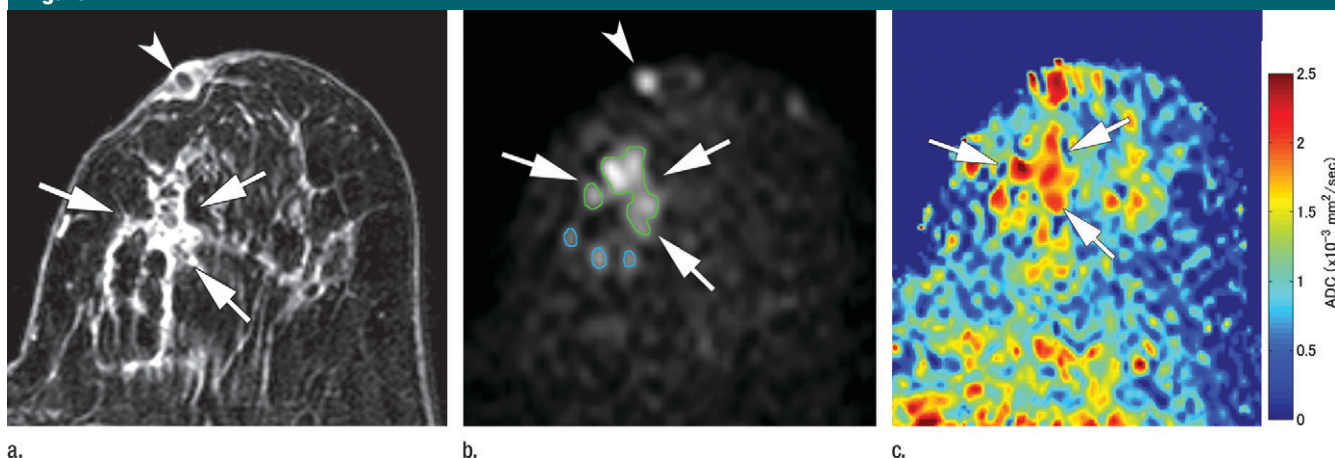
Low-grade DCIS (arrows) in a 68-year-old woman. (a) Dynamic contrast-enhanced MR image obtained in early phase, (b) diffusion-weighted MR image ($b = 1000 \text{ sec/mm}^2$), and (c) ADC map. In c, lesion has orange-red contours (corresponding to high ADC). In b, only ROIs outlined in green were analyzed; blue ROIs were excluded because they were smaller than 20 mm^2 . The area of high signal intensity (arrowhead) on b was not outlined because it did not enhance on contrast-enhanced image (arrowhead). This area turned out to be nipple discharge.
